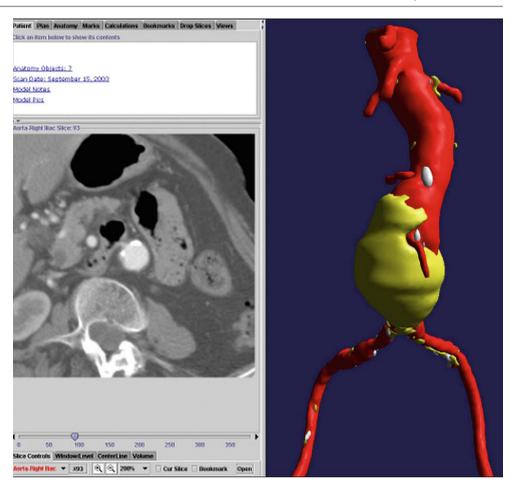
Large abdominal aortic aneurysm by CT. In this case, palpation easily confirms diagnosis and size. CT scan was performed for evaluation for rupture
